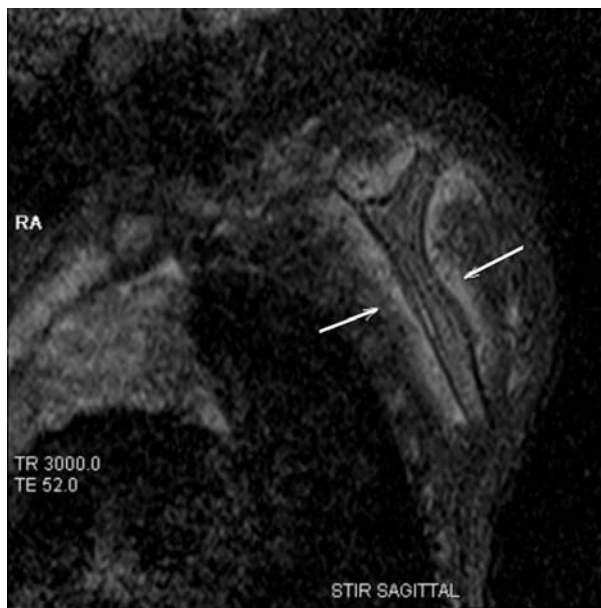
MRI showing altered signal intensity in the body of left scapula with periosteal reaction.
